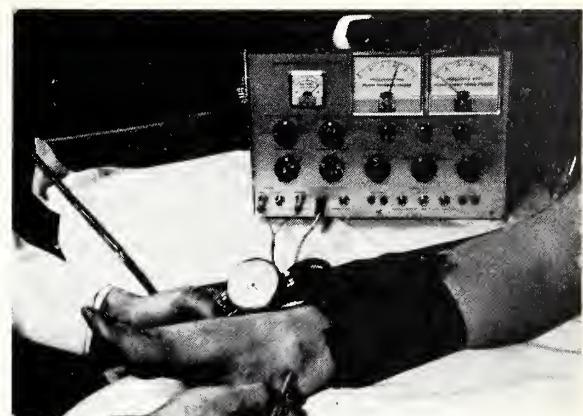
Flow detection and measurement of ankle systolic pressure by the Doppler ultrasound method.
